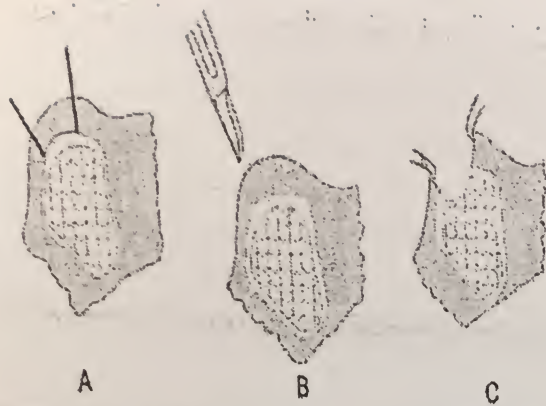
A. radiographic splint
